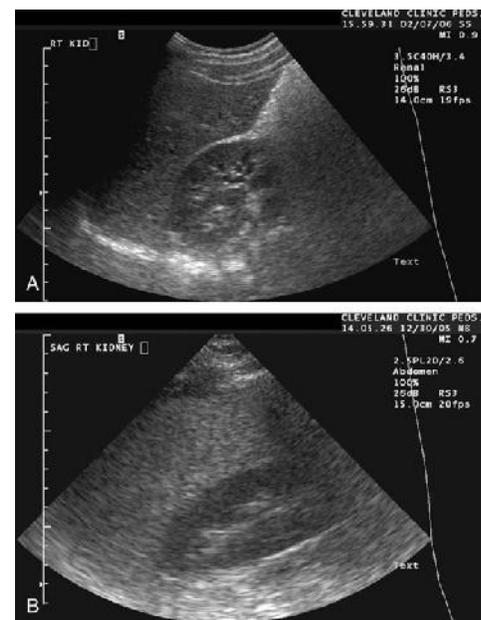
Sonographic features in fatty liver. A, Normal liver: same echogenicity as the kidney. B, Fatty liver: increased echogenicity compared with the kidney
